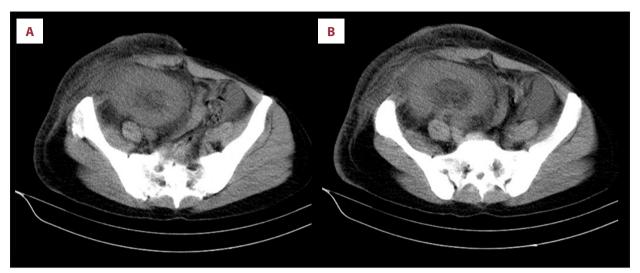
(A, B) Abdominal and pelvic CT-Scan of a 32-year -woman showing severe enlargement of transplanted kidney and edematous abdominal wall. This CT scan demonstrates intra-pelvis fluid accumulation that firstly suspected to be hydronephrosis.
